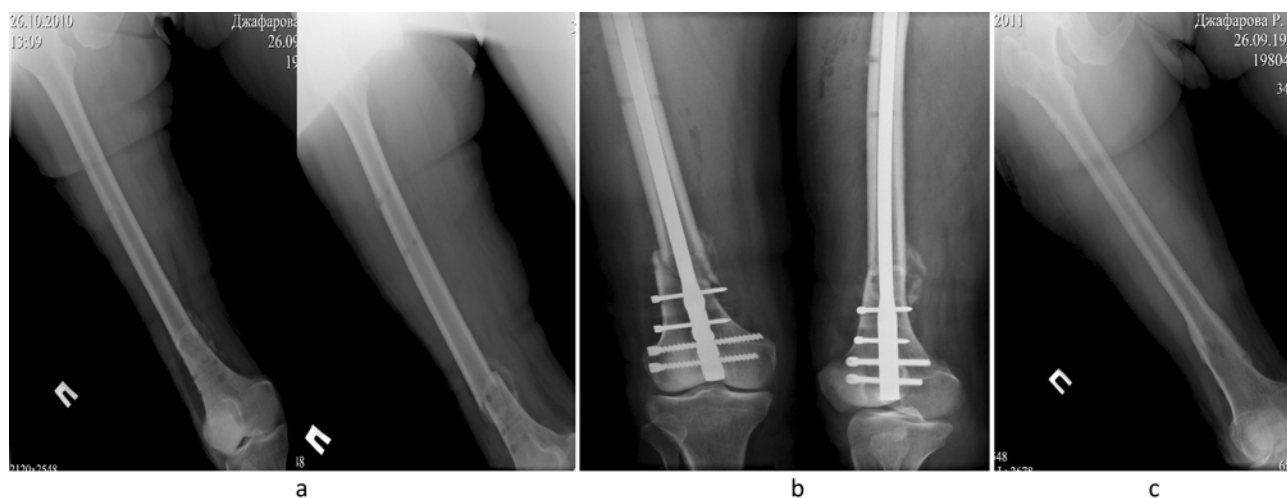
Radiographs of the distal femur (right side) of a female patient D. showing (a) preoperative view, (b) intraoperative view and (c) bone consolidation with metal construct removed 12 months following surgical intervention
